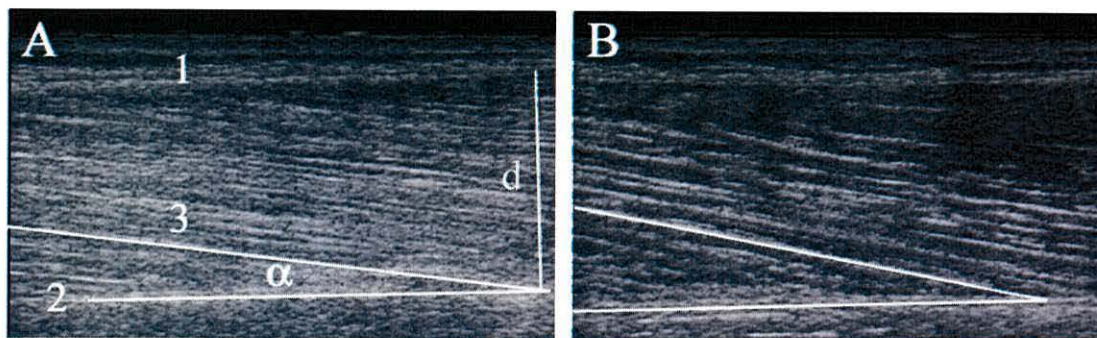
Sagittal-plane sonographs of the vastus lateralis muscle of a patient with rheumatoid arthritis (A) and a healthy control (B). Note the greater pennation angle (θ) in the muscle of the healthy control. 1 = superficial aponeurosis, 2 = deep aponeurosis, 3 = fibre fascicles; θ is the angle of insertion of the fibre fascicle into the deep aponeurosis of the VL.
